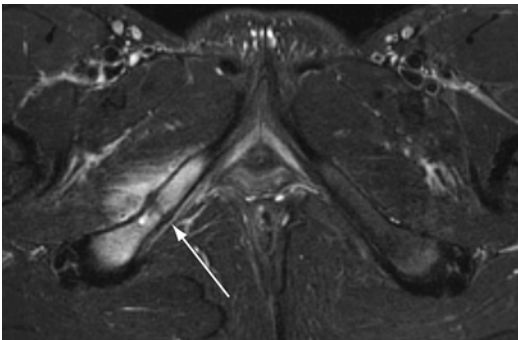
Pubic ramus stress fracture. Axial STIR image demonstrates a stress fracture of the right inferior pubic ramus (*arrow*) with intense surrounding marrow edema and periosteal edema. The abnormality was radiographically occult due to the oblique orientation of the pubic bone
